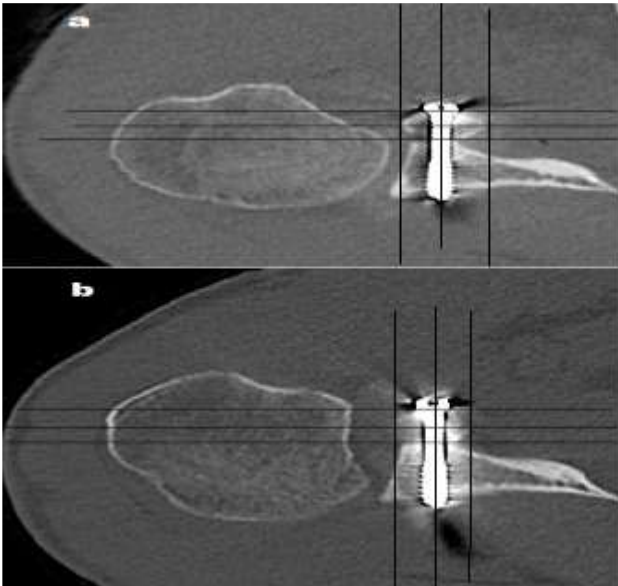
CT scan showing the coracoids bone graft around distal screw:
